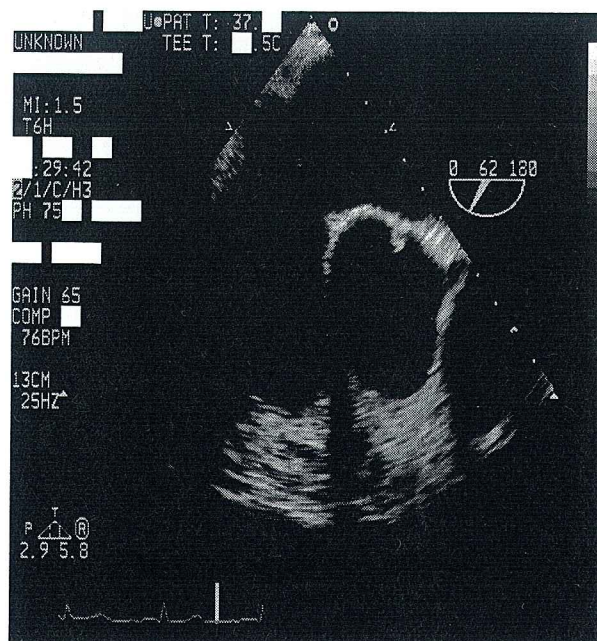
Standard cardiac B-mode ultrasound image with burned-in information masked
